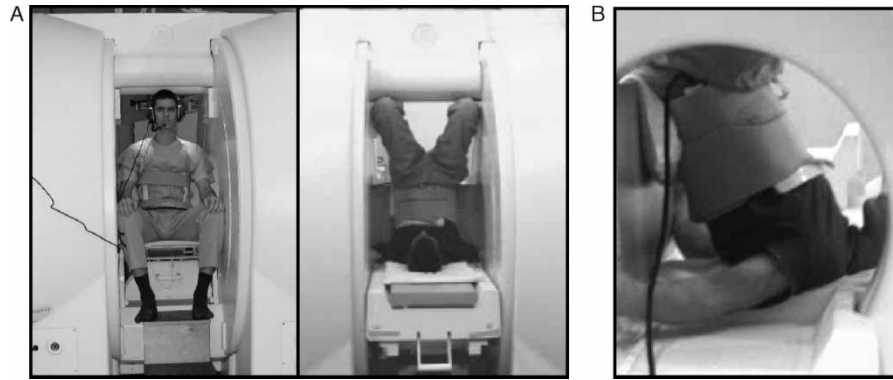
a. The 0.5 T open configuration MRI system with a volunteer in seated position (SP) (*left*) and upside-down position (UDP) (*right*). b. In UDP the long axis of the stomach was always at an angle steeper than 45° to the horizontal scanner table. The standard abdominal surface coil was fixed around the subject's abdomen.
